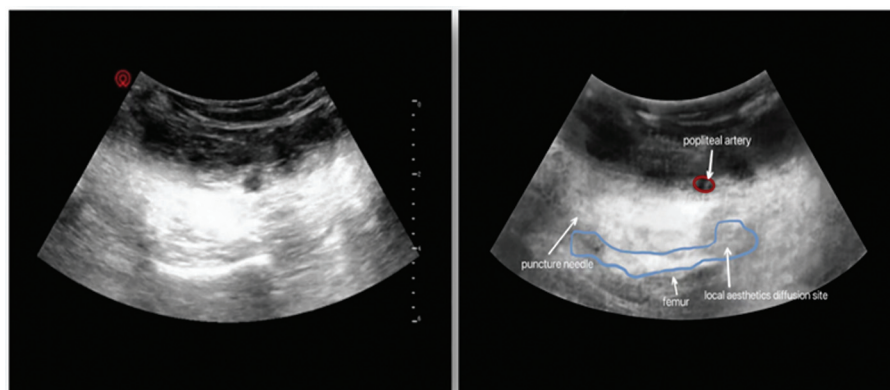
Ultrasound image of infiltration between the popliteal artery and capsule of the posterior knee block.
